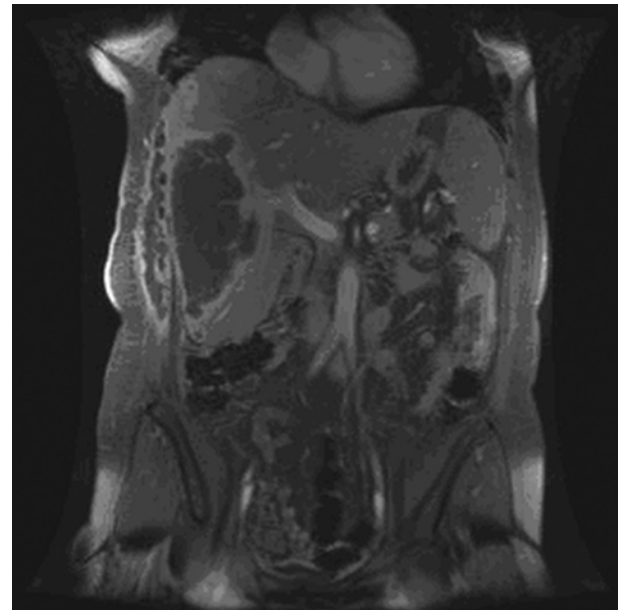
Coronal MRI showing the relative location of the liver lesion and muscle thickening.
